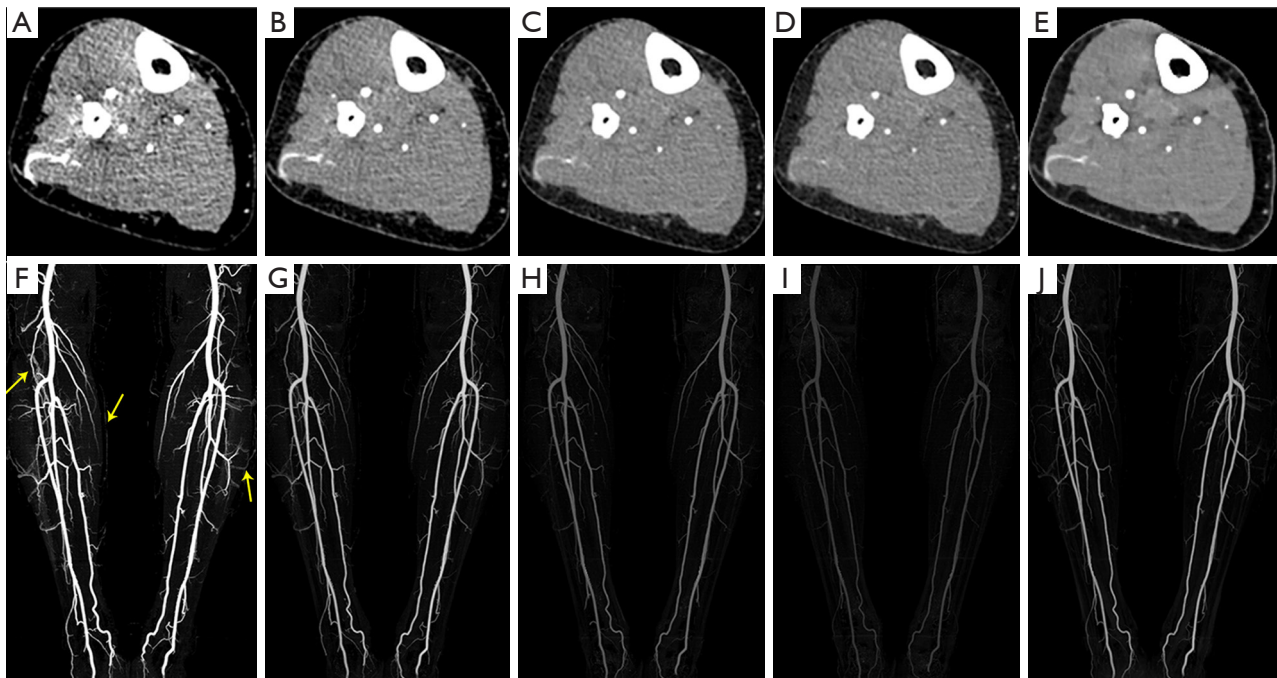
A 72-year-old female patient with oral cancer underwent DECT imaging. VMI reconstructions at 40 and 60 keV could meaningfully increase vascular attenuation and raise the enhancement of vessels. (A-E) VMI reconstructions at levels of 40, 60, 80, and 100 keV, and the M_0.5-C image, respectively. (F-J) MIP imaged at 40, 60, 80, and 100 keV, and the M_0.5-C image, respectively. Severe venous contamination was found on the 40-keV VMI reconstructions (arrows), and the 60-keV VMI reconstructions showed the best image quality. DECT, dual-energy computed tomography; VMI, virtual monoenergetic imaging; keV, kiloelectron volt; M_0.5-C, 0.5 linear image blending image from the arterial phase; MIP, maximum intensity projection.
